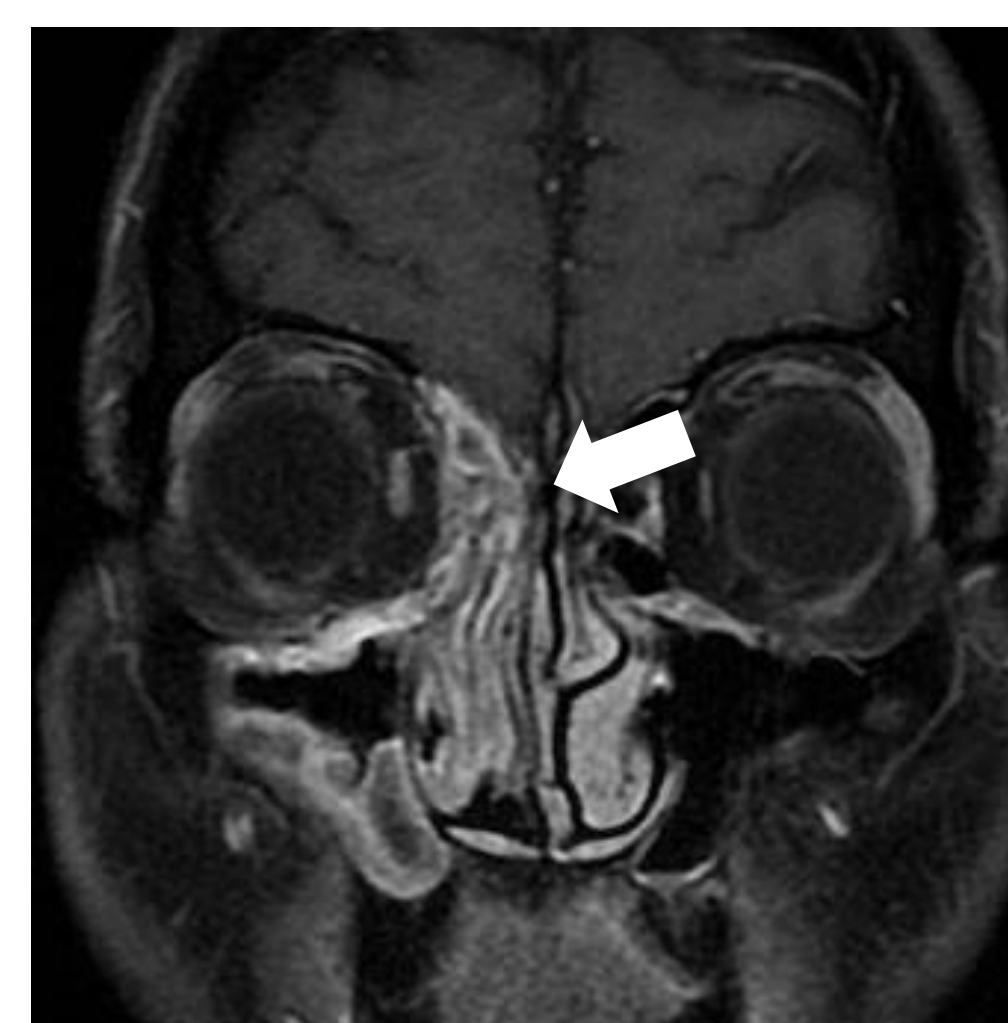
Enhanced MRI of case1
